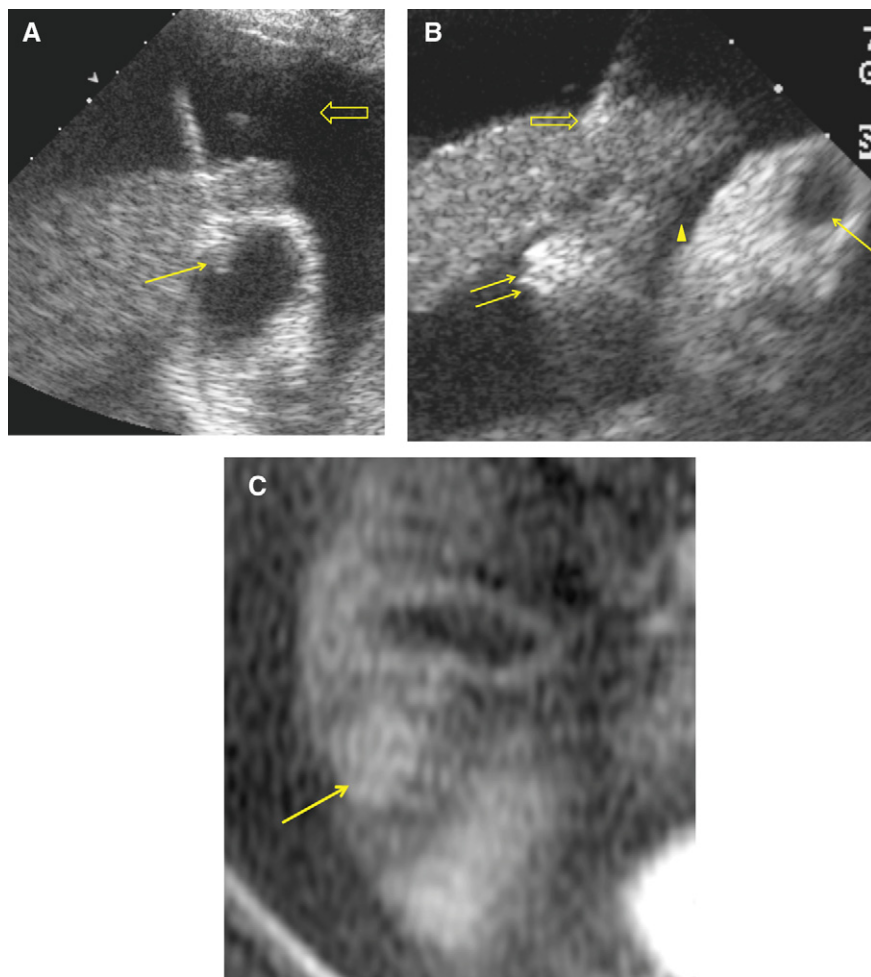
(A) Ultrasound image, showing percutaneous needle decompression of the previously distended gallbladder through a transhepatic approach (arrow); a large volume of ascites surrounds the gallbladder (open arrow). (B) Ultrasound image obtained more inferiorly during radiofrequency ablation, showing the decompressed gallbladder (arrow), now retracted from the liver surface with intervening ascites noted (arrowhead); the radiofrequency electrodes enter segment 5 of the liver (open arrow); echogenic foci (double arrow) demarcate the developing subcapsular hepatic ablation zone. (C) Axial contrast-enhanced T1-weighted magnetic resonance image obtained 1 day after ablation, showing expected mild hyperintensity of the ablated tumour (arrow); there was no residual tumour enhancement, and the ablation zone margin around the tumour was satisfactory; the ablation zone extends to the liver capsule adjacent to the peritonealized surface of the gallbladder, with no gallbladder injury evident.
